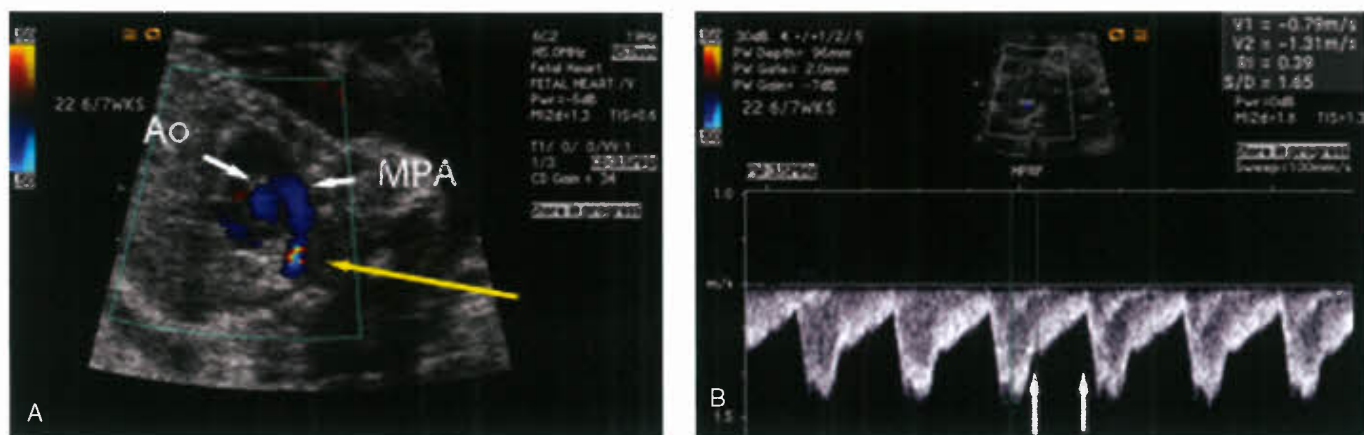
A: Fetal echocardiogram with color-flow mapping showing constriction of the ductus. B: Spectral Doppler image of a fetal ductus showing continuous right-to-left flow with abnormally high diastolic velocities.
